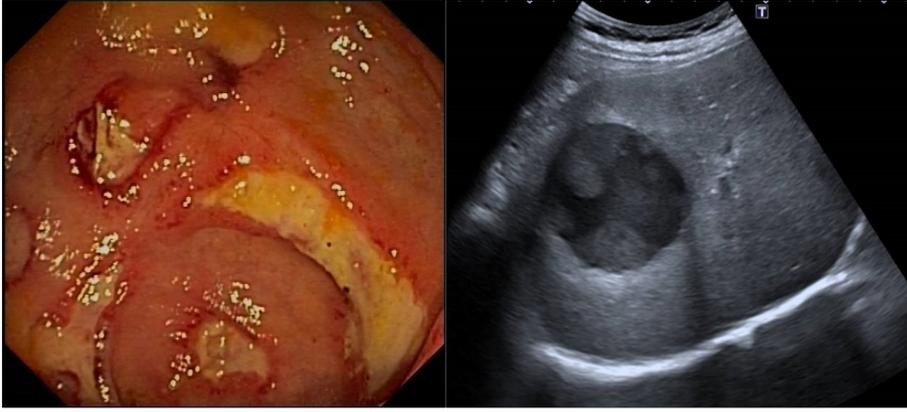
A. Colonoscopy. Numerous deep ulcers covered with fibrin, ranging from 5 mm to 3 cm in size, were observed in the caecum and right colon, suggestive of an infectious etiology. B. Ultrasound. Normal-size liver with preserved echotexture and smooth edges. A heterogeneous lesion measuring 68 x 61 mm is identified in segments V, VI, and VIII, with echoes inside, consistent with a liver abscess.
